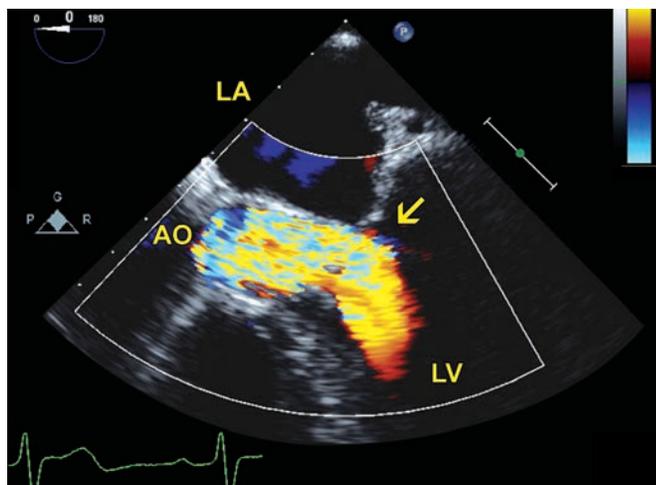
Transesophageal echocardiography with color Doppler showing mosaic turbulent outflow at the subaortic level (arrow) indicative of obstructive physiology.
